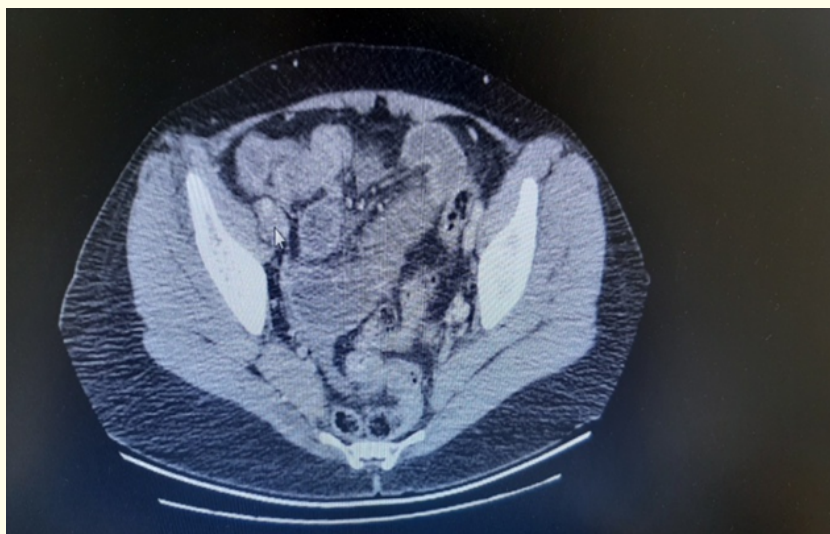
The Computed tomography (CT) shows the mass narrowing the ileocecal region.
